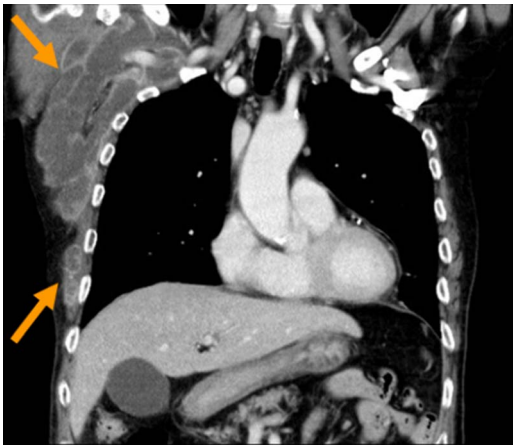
Chest computed tomography showing a multilocular abscess in the right-sided chest (arrows).
